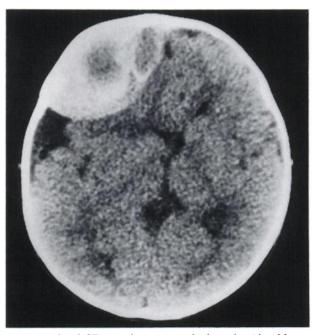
A head CT scan showing a right frontal epidural hematoma with a midline shift.
